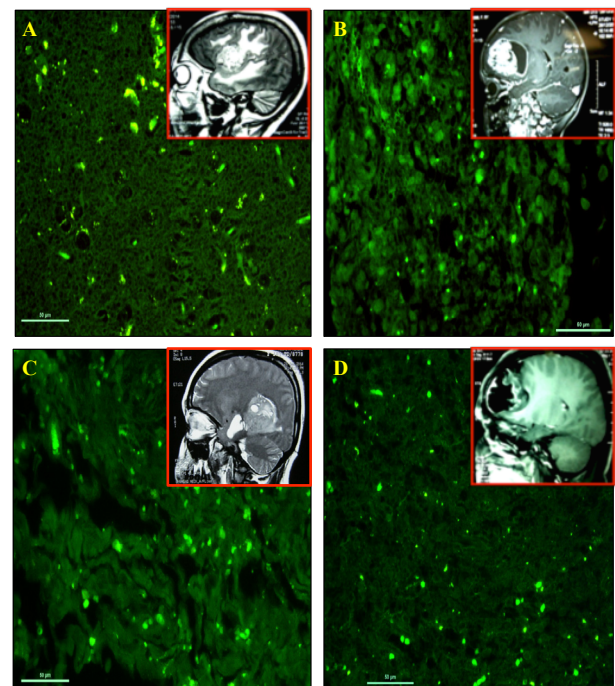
T1 Weighted MRI Records with Alexa Fluor® 488-Conjugated GFAP Expression. Note increased expression of GFAP (glowing green) along with visible heterogenous tissue matrix at growing levels in (A) astrocytoma II (B) astrocytoma III (C) astrocytoma IV and (D) oligoastrocytoma grade II. Magnification 40X
